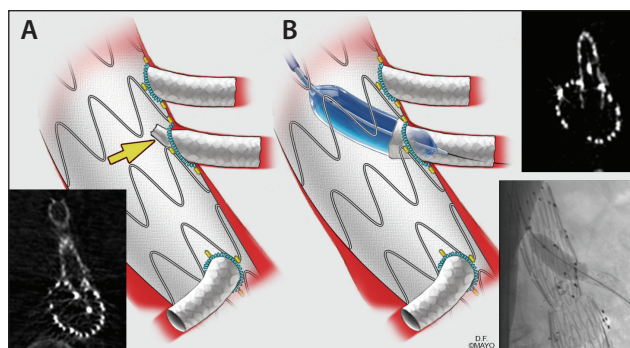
Completion cone-beam CT (CBCT) shows compression of the superior mesenteric artery bridging stent (A, yellow arrow). This was immediately revised by balloon angioplasty (B) with resolution of the compression on repeat CBCT. Used with permission of Mayo Foundation for Medical Education and Research. All rights reserved.
